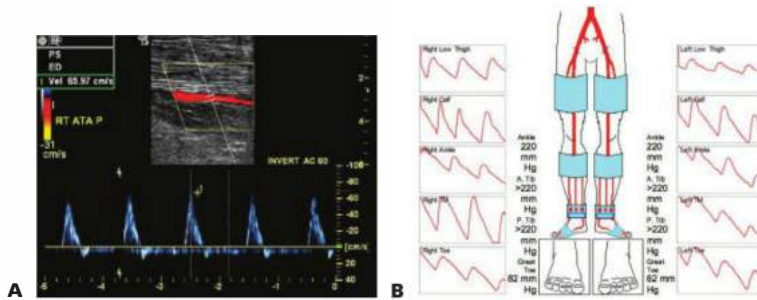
• A. Duplex of the anterior tibial artery postrecanalization and angioplasty shows patent vessel with relatively normal Doppler flow. B. Follow-up PVRs postrecanalization and angioplasty of the right anterior tibial artery and right posterior tibial artery demonstrates normal PVR waveforms in the foot with adequate toe pressure.
